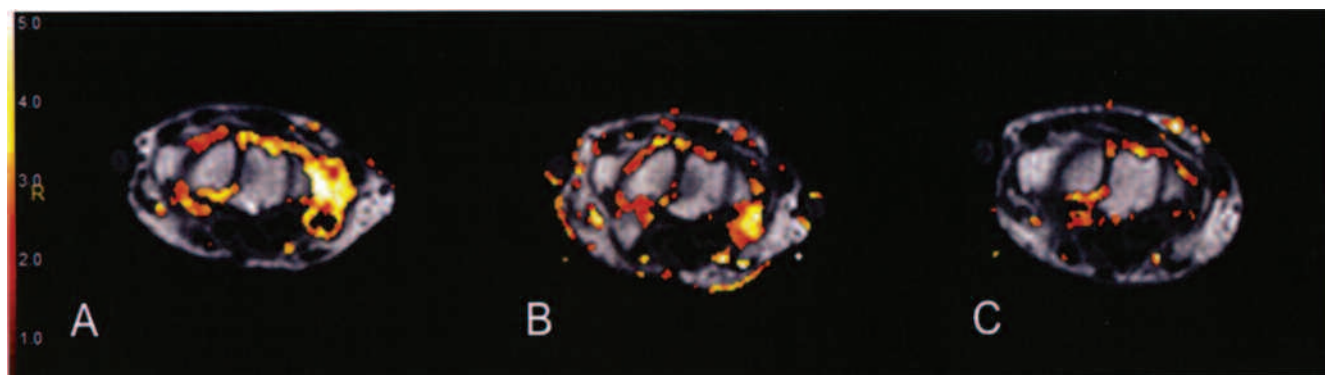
Dynamic, contrast-enhanced magnetic resonance imaging maps of the wrist in a patient with psoriatic arthritis during anti-tumor necrosis factor- α treatment, at baseline (A), and after 1 month (B) and 6 months (C) of therapy. Note the clear decrease of enhancement in the joint synovial membrane and in the synovial sheath of the flexor carpi radialis.
